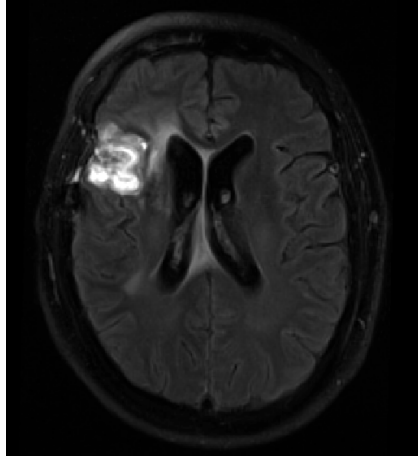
T_2 weighted FLAIR MRI in a recurrent glioma patient. The sequence suppresses signal from free fluids, thus the ventricles appear dark. With removal of the hyper intense signal from free fluids, it causes a strong T_2 weighting for detection of fluids bound in tissue (edema) as can be found in the surrounding of the lesion.
